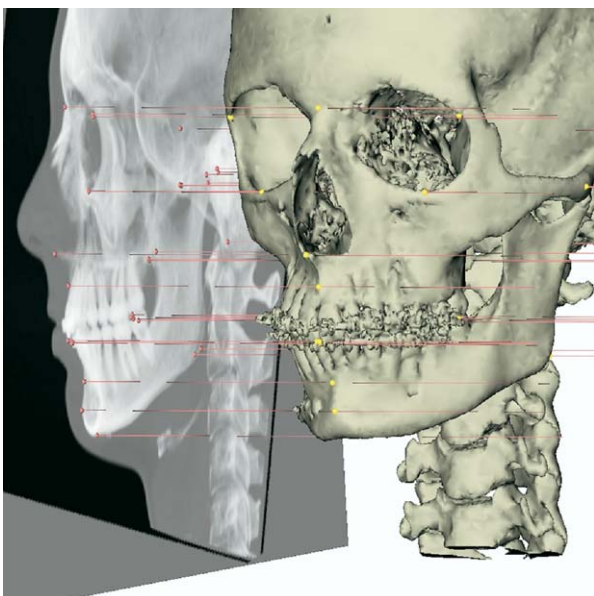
Virtual lateral cephalogram linked to 3D hard-tissue surface representation with setup of 3D cephalometric hard-tissue landmarks (MS-CT).
